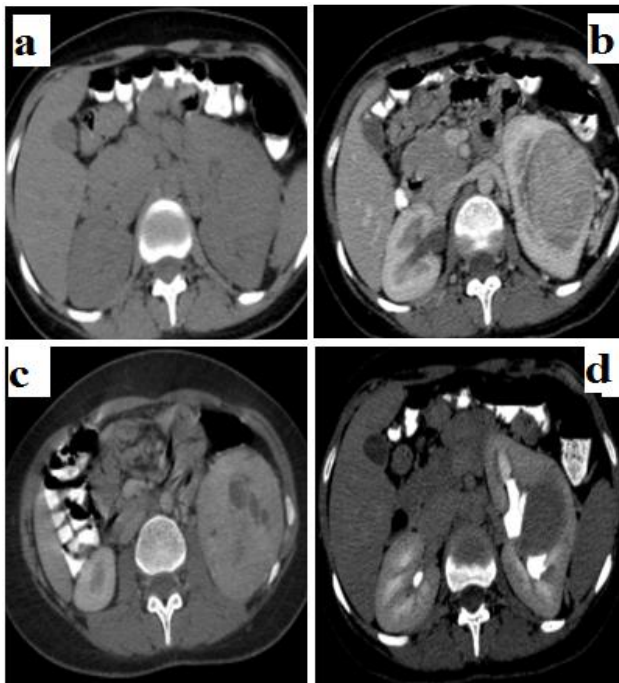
a) Axial unenhanced CT showing a isodense renal mass involving the midpole of left kidney. (b) and (c) axial corticomedullary and nephrographic image showing heterogenous enhancement of mass and cystic changes with pseudocapsule. (d) axial excretory phase showing mass extension up to pelvicalyceal system with splaying of calyces.
